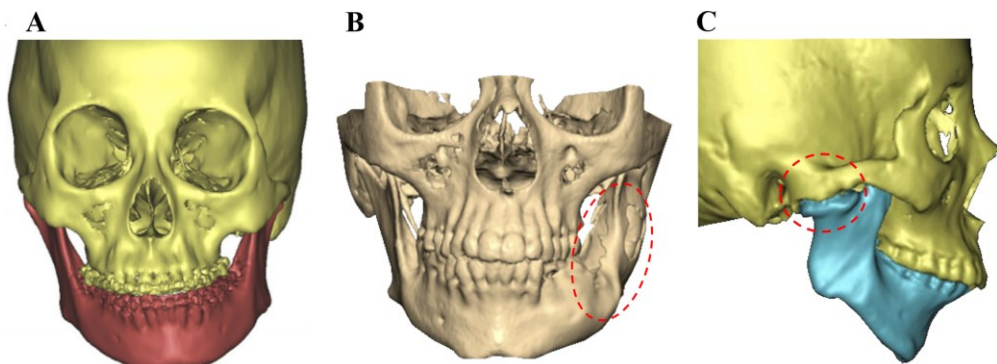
Segmented preoperative facial bones from CT datasets. A – 3D facial bones in order to evaluate skeletal asymmetry (53), B – 3D facial bones in order to evaluate the size of a tumor (54), C – 3D facial bones in order to evaluate the ankylosis of the temporomandibular joint (TMJ) (55)
